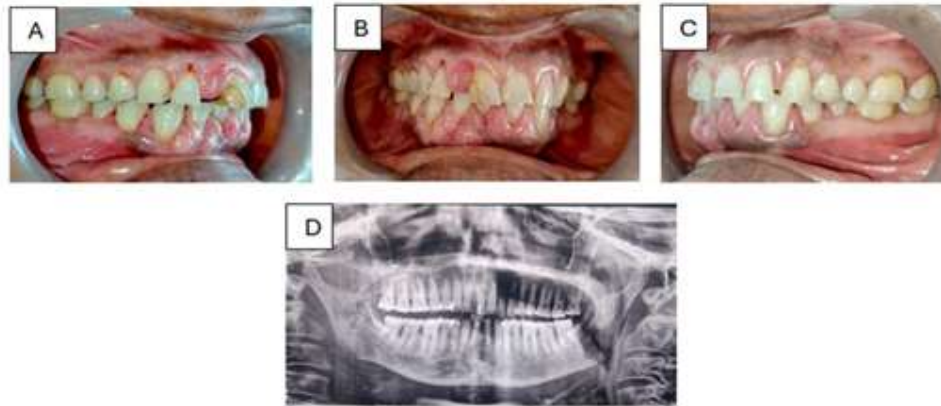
A) to C) Frontal and profile images before phase 1 therapy; D) Orthopantomogram
